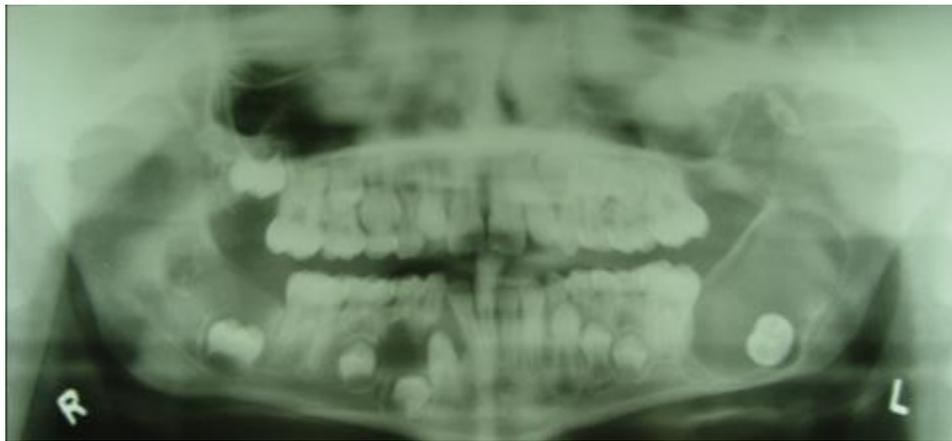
e.- Panoramic radiograph showing a radiolucent shadow on the left side with destruction from a retained lower third molar.
